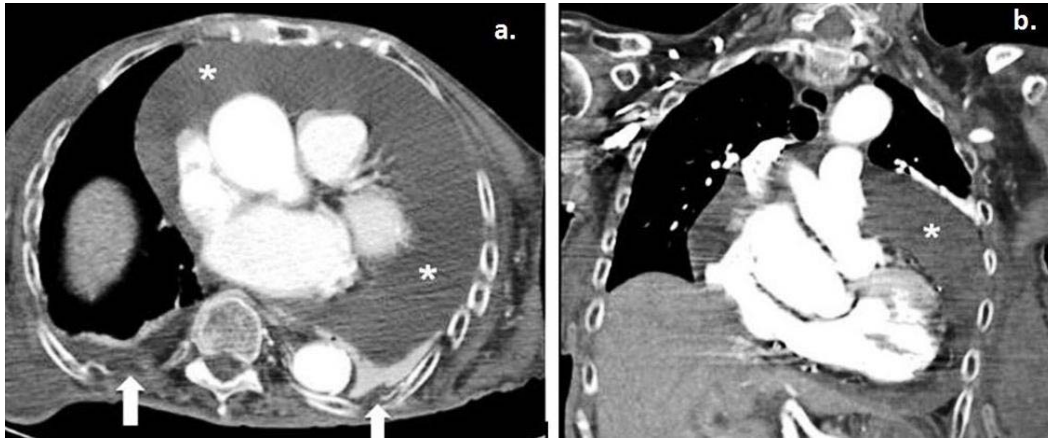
a. Axial contrast-enhanced computed tomography and coronal maximum intensity projection–reconstruction during the patient’s hospitalisation revealed a large global pericardial effusion (*). b. Small bilateral pleural effusions are also noted (white arrows).
